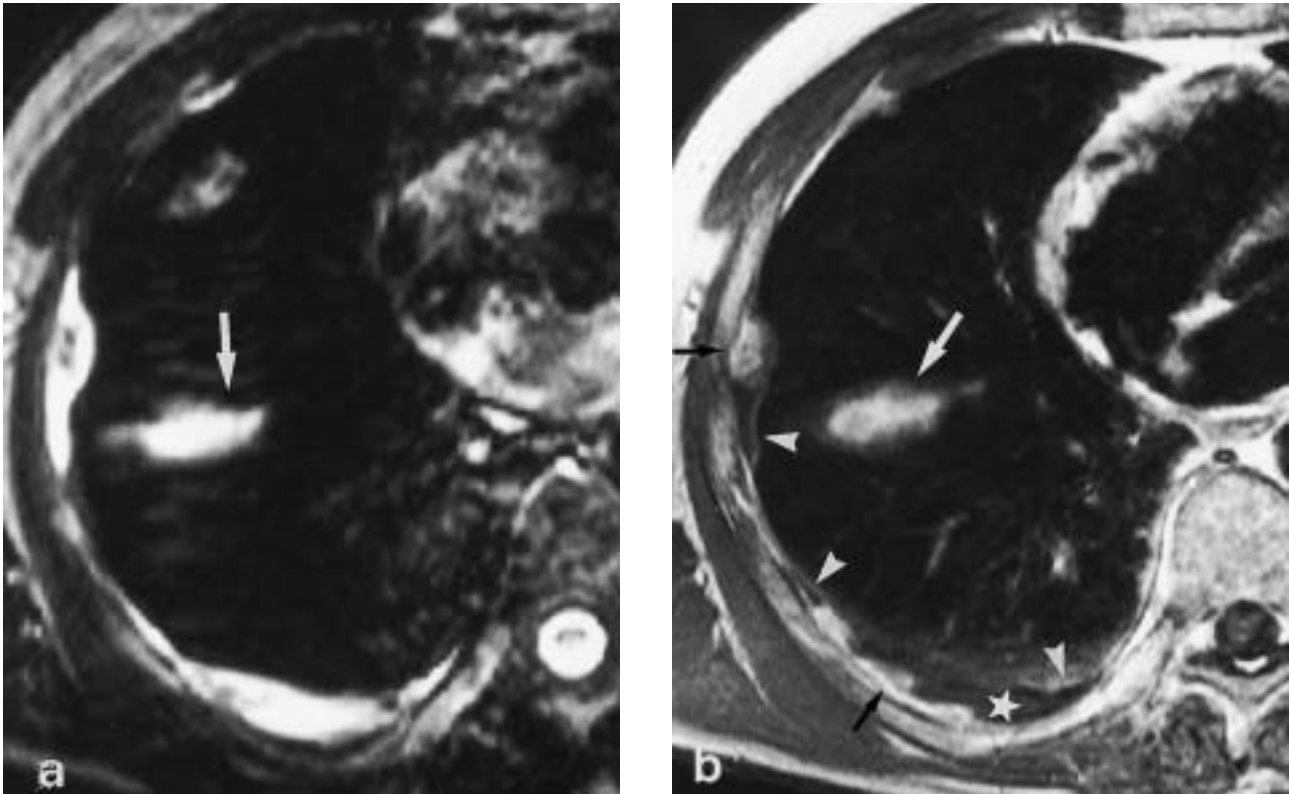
Primary pleural liposarcoma. a) Transverse T2-weighted magnetic resonance image displays pleural and fissural (arrow) changes with high signal intensity. No reliable distinction of pleural effusion and tumourous changes. b) Corresponding contrast-enhanced T1-weighted image. Excellent differentiation of enhancing irregularly defined parietal tumour nodules (black arrows), non-enhancing effusion (star), slightly thickened visceral pleura (arrowheads), and fissural tumour involvement (white arrow).
